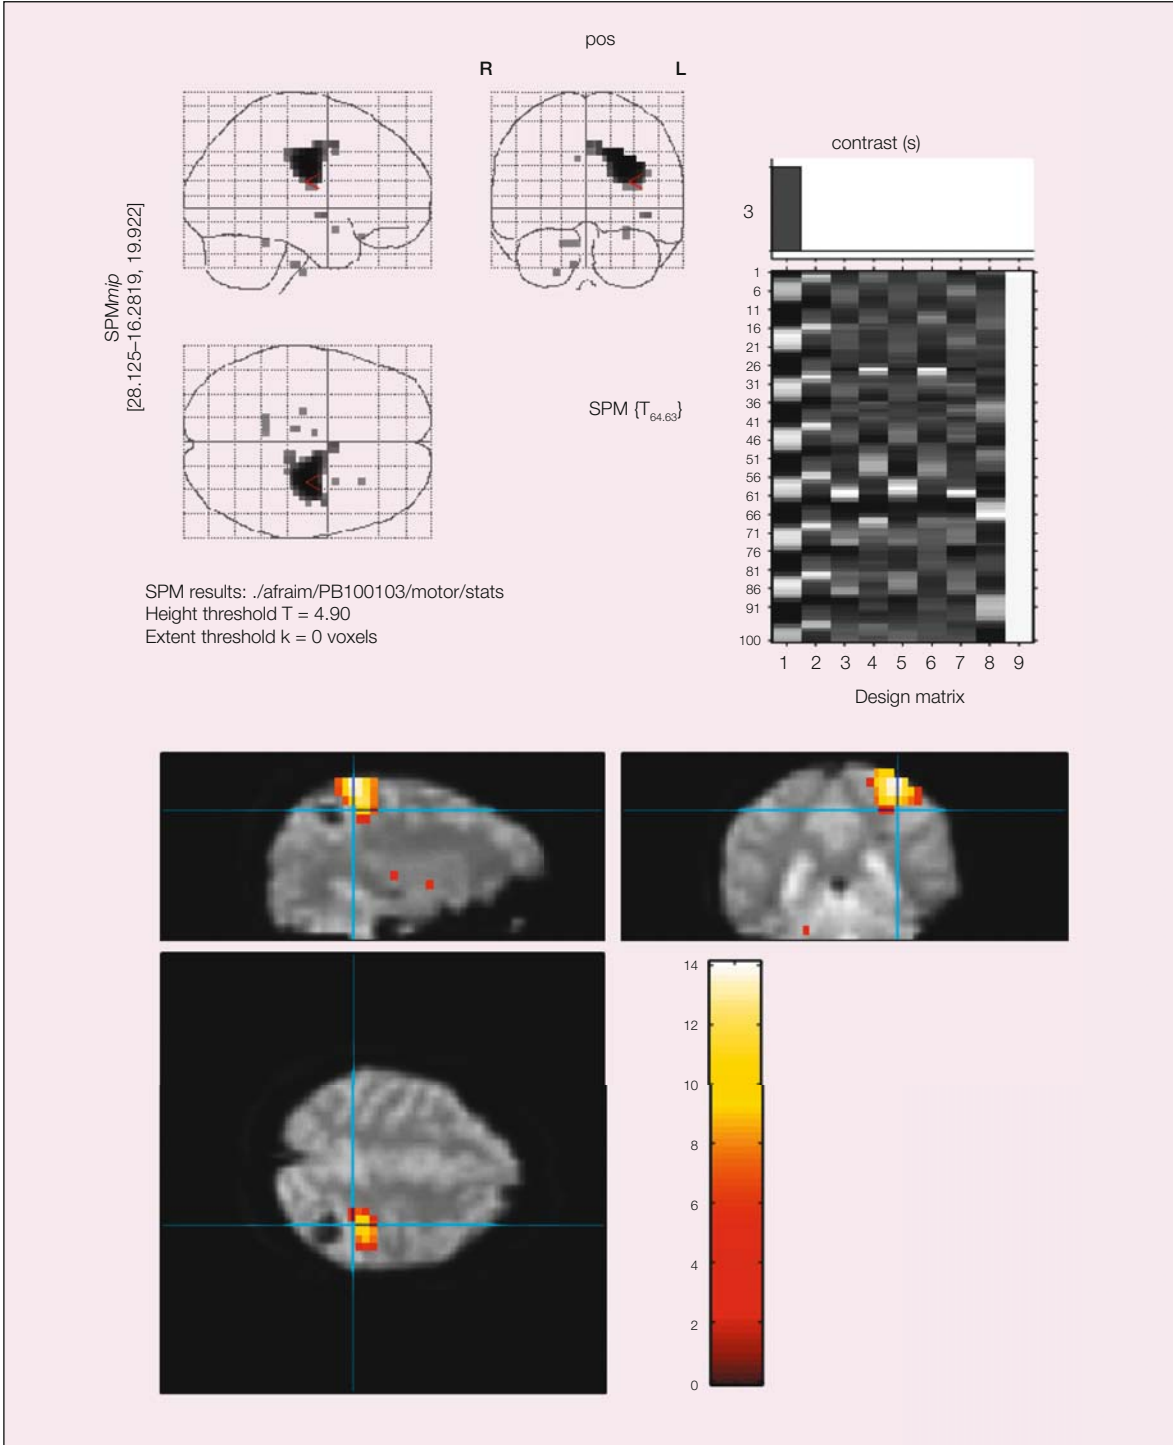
Courtesy of Professor John S. Duncan and the National Society for Epilepsy MRI Unit, UK.
